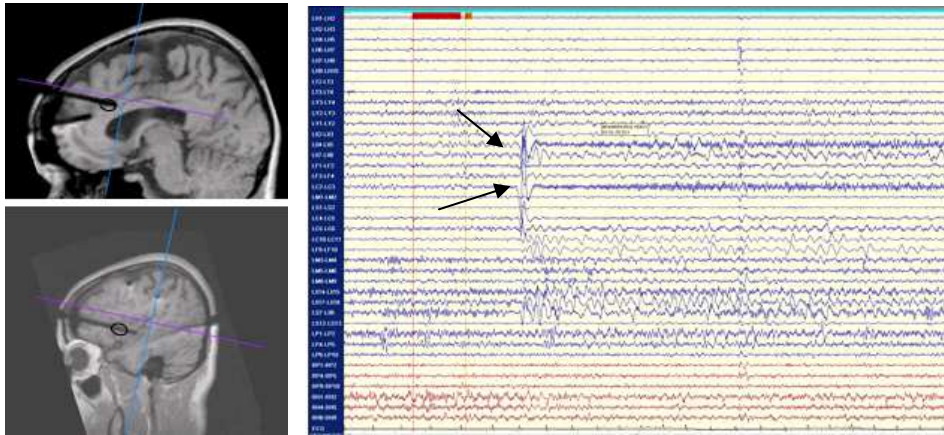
Left: 1.5T MRI with SEEG in situ. Top: contacts LC 1-4 encircled. Bottom: contacts LX 4-6 encircled. Right: bipolar SEEG traces at the beginning of a seizure. Seizure onset with high amplitude wave followed by gamma-activity on contacts LC 2-3 (left anterior cingulum) and contacts LX 4-5 (left anterior insula). Contacts LC 2-3 correspond with highlighted
